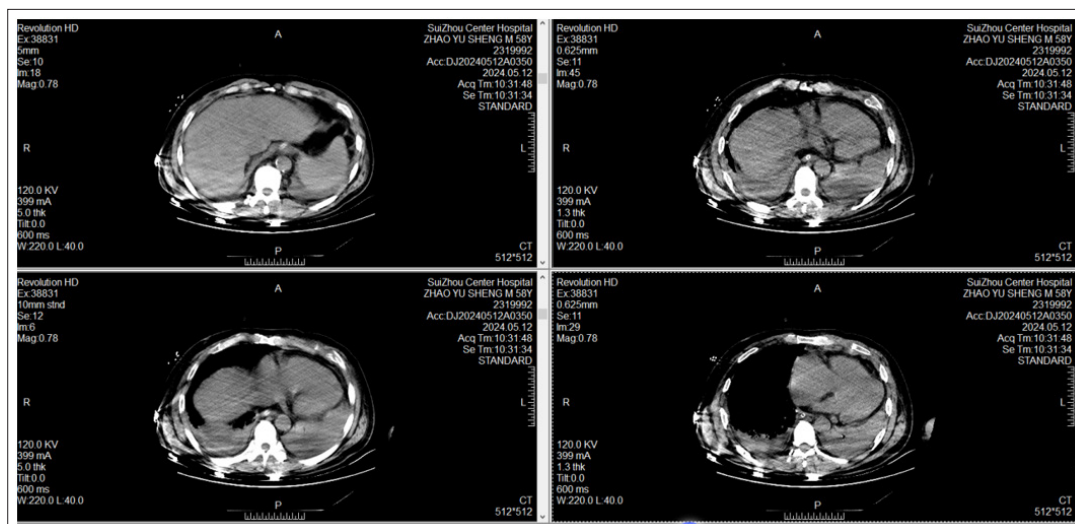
CT on May 12 showed calcification and suspicious dissection in the descending aorta. Lower abdominal and pelvic effusion (hematosis), similar to the ratio of May 10, it is recommended to combine clinical and review
